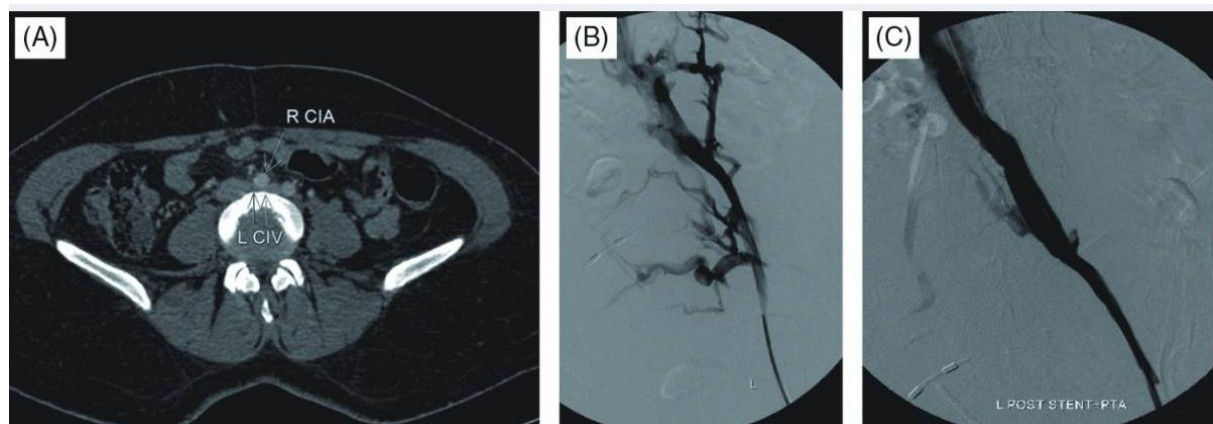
A 44-year-old female who presented with the left lower extremity and inguinal varicosities. (A) A transverse computed tomography image shows the right common iliac artery (single arrow) compressing the left common iliac vein (double arrow). (B) Initial venography revealed significant stenosis of the left common iliac vein with extensive cross-pelvic and hypogastric collateralization. (C) Venography performed after thrombolysis with following stent implantation and angioplasty revealed complete resolution of collateral filling with good flow through the femoral and iliac system into the IVC
